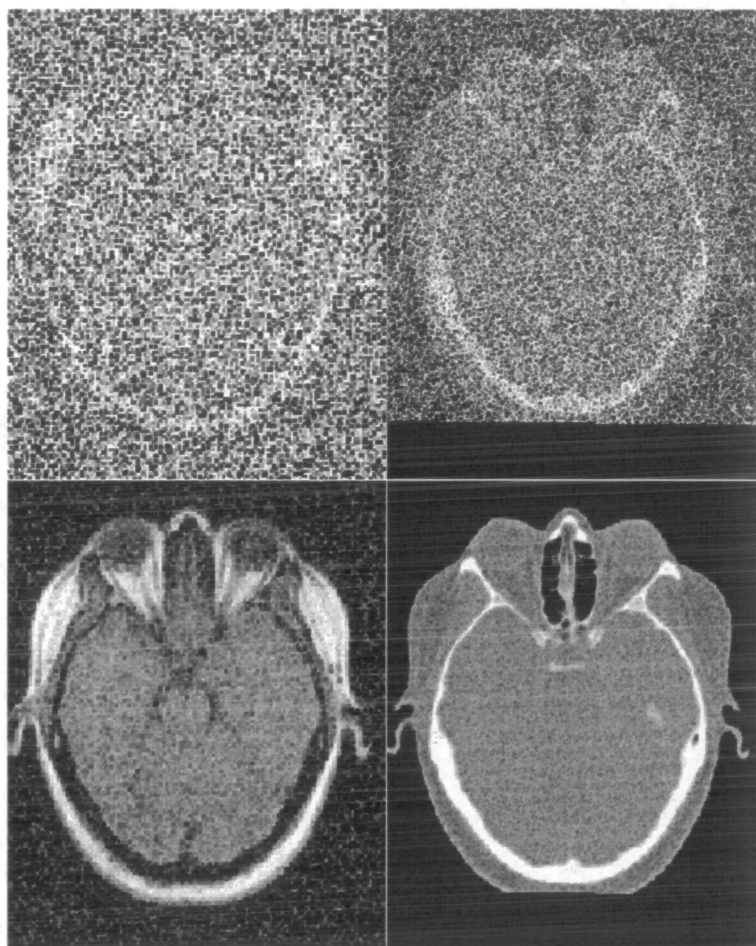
Examples of two levels of additive Gaussian noise used in experiments, left MR, right CT. Upper image is with added Gaussian noise with a standard deviation of 80% of the dynamic range. Lower image is with added Gaussian noise with a standard deviation of 10% of the dynamic range.
